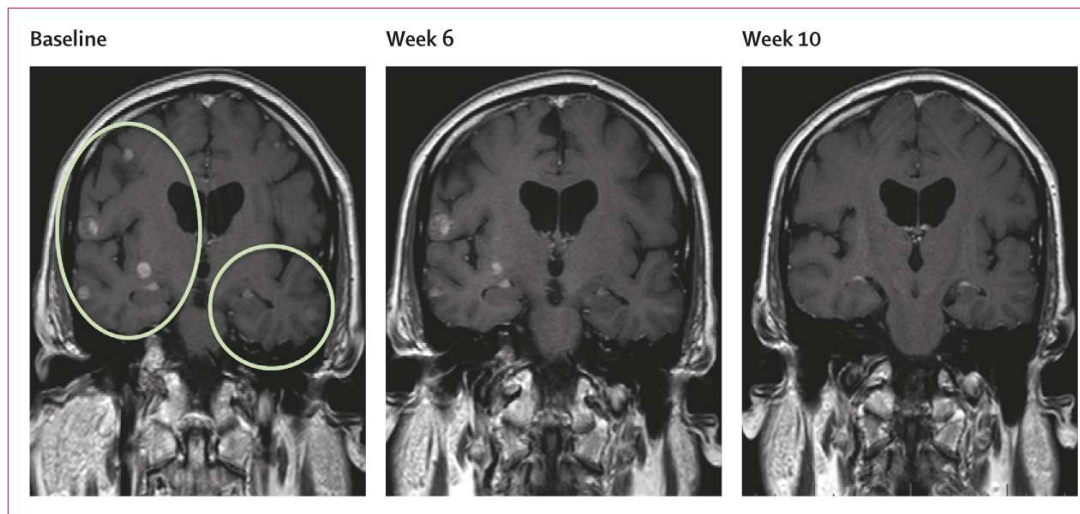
MRI images from one patient with Val600Glu BRAF-mutant melanoma and untreated brain metastases given the recommended phase 2 dose. Image from baseline (left), week 6 (middle), and week 10 (right). Circles indicate locations of lesions. Best response was a 71% decrease in tumour size, and the best intracranial decrease was 68%.
